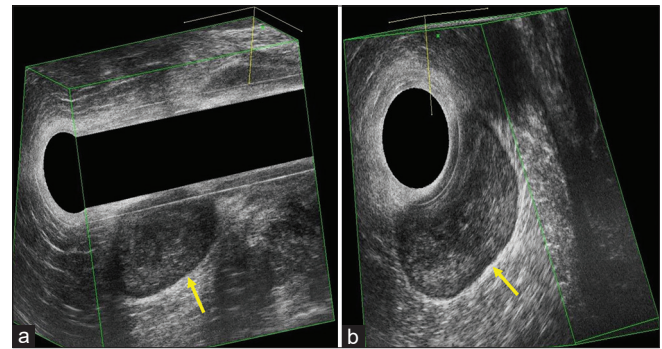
The tumor was presented as circumscribed lesion with homogeneous structure at EAUS (a and b) (marked by arrow). EAUS: Endoanal ultrasonography
